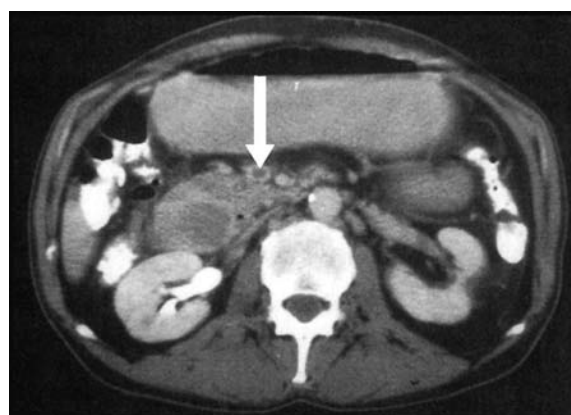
Abdominal computed tomogram of a patient with acute mesenteric venous thrombosis. *Arrow*, thrombus in the superior mesenteric vein. (From Rhee RY, Gloviczki P. Mesenteric venous thrombosis. *Surg Clin North Am.* 1997;77:327-38. Used with permission.)
